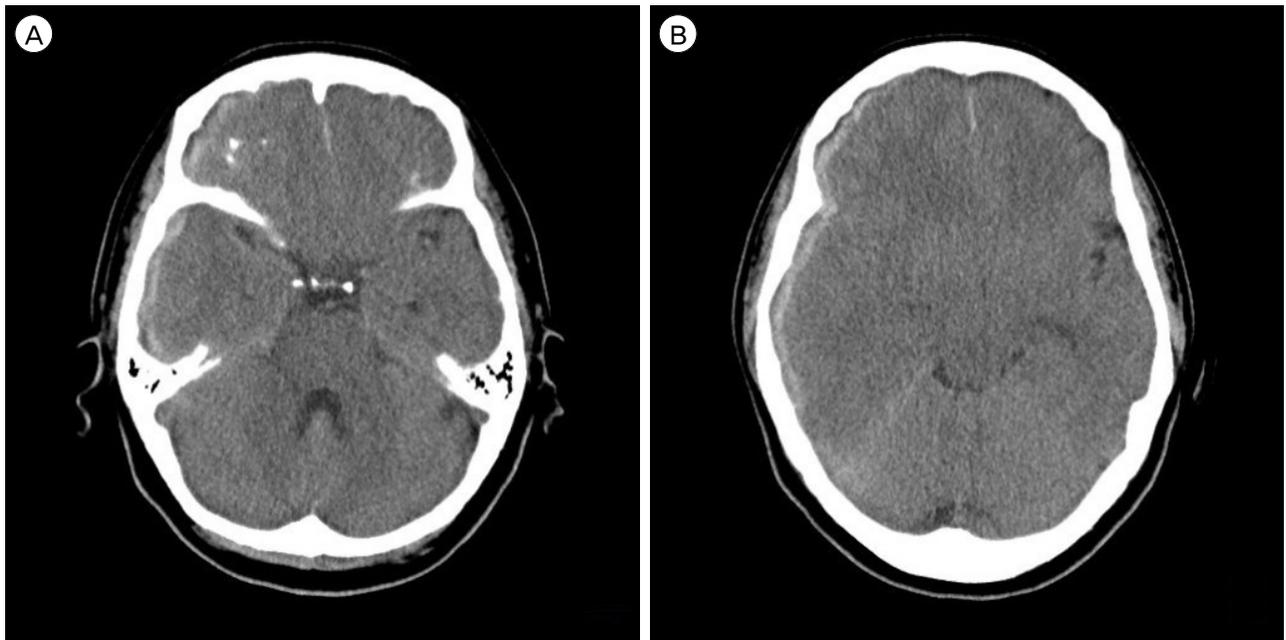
Initial brain imaging findings of case. Computed tomography scans (A, B) shows no evidence of subarachnoid hemorrhage at the basal cistern and the sylvian fissure and there is only acute subdural hematoma on the right fronto-temporo-parietal area.
